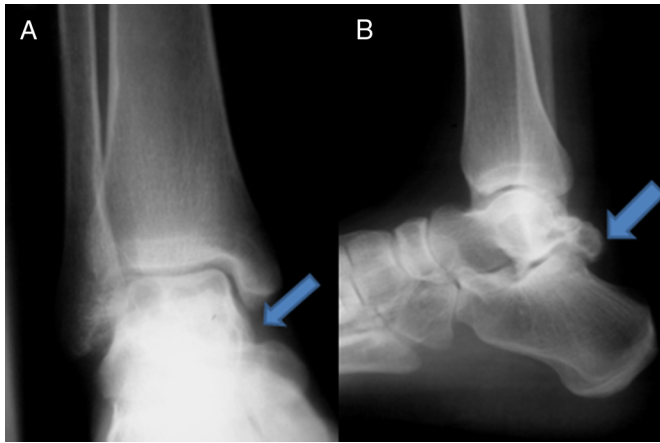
Radiographs of ankle in anteroposterior (A) and lateral (B) projections showing an exostosis arising from posteromedial aspect of talus (arrows).
